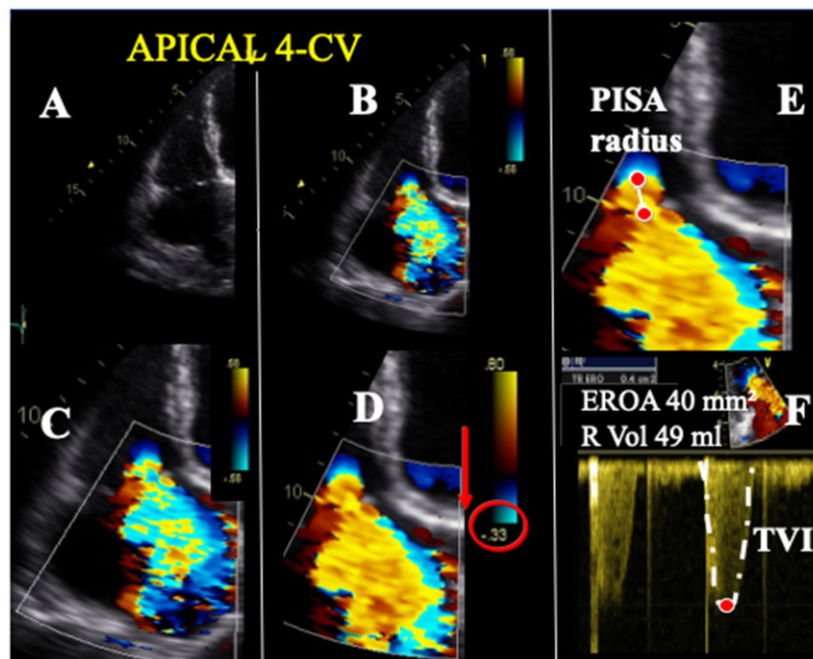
Quantitative assessment of TR severity using the PISA method. Stepwise analysis of TR. (A) Apical four-chamber view (CV); (B) colour-flow display; (C) zoom of the selected zone; (D) downward shift of zero baseline to obtain a hemispheric PISA; (E) measure of the PISA radius using the first aliasing; and (F) continuous wave Doppler of TR jet allowing calculation the effective regurgitant orifice area (EROA) and regurgitant volume (R Vol). TVI, time-velocity integral.
